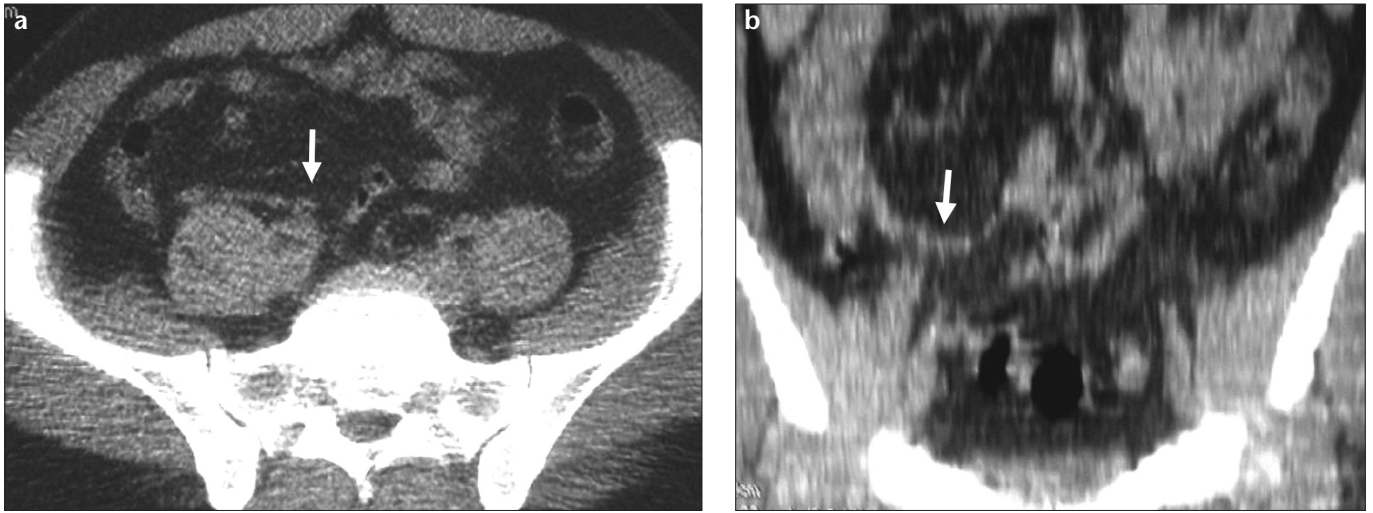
Axial CT section (a) and coronal MIP image (b) show an appendix (arrow) extending to the midline.
